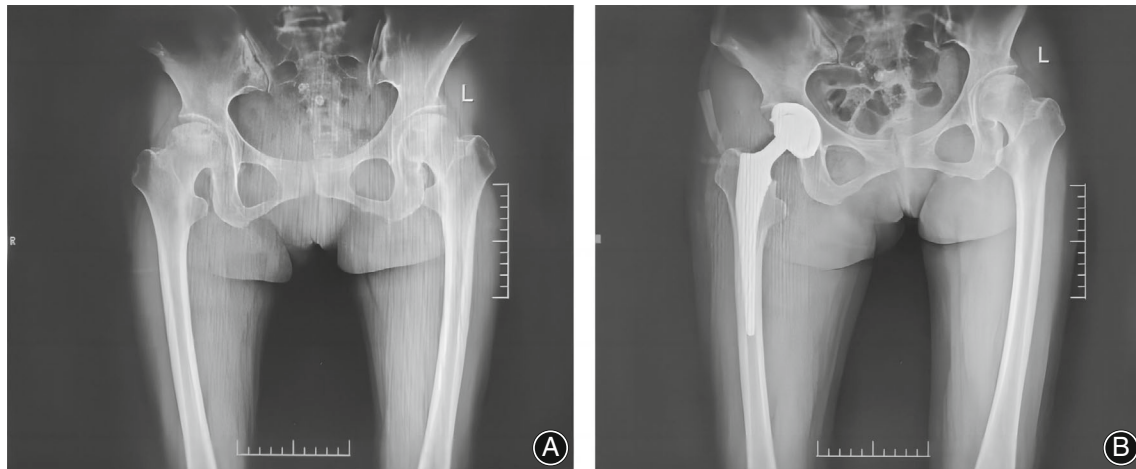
The preoperative and postoperative radiographic changes in the hip joints of one elderly patient with CKD (Anteroposterior Pelvic Radiograph). (A) The femoral heads' bone mineral density (BMD) was inhomogeneous, and there were low-density zones under the articular surface. The lesion at the right is distinct compared with the left side. (B) The artificial joint was visible in the right hip joint with a good position and no radiological signs of implant loosening.
